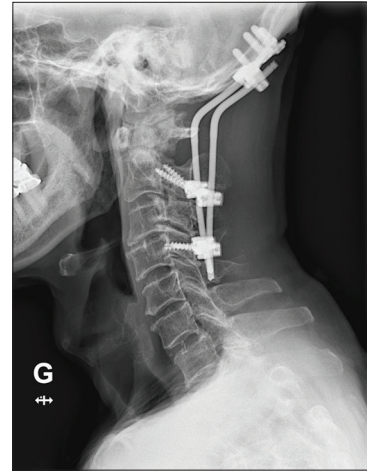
Lateral cervical X-ray done postoperatively at 6 months' time showing intact hardware.
